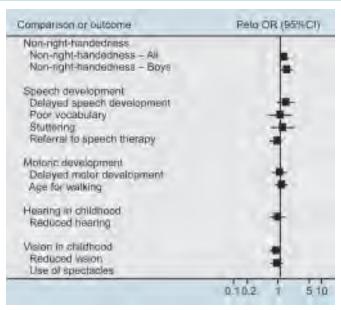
Meta-analysis of Nordic and Swedish studies on routine ultrasound during pregnancy and childhood neurological development
